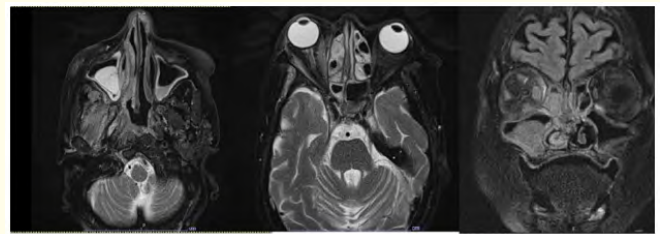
MRI of the Orbits shows right OPN and invasive fungal sinus infection.
